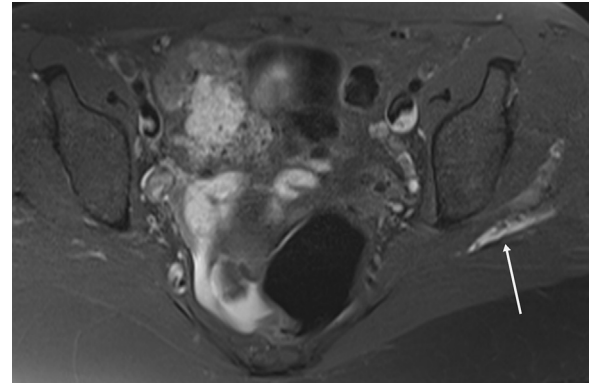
Axial PD fluid sensitive MRI. There is fluid tracking along the left gluteus medius myotendinous junction (white arrow).
